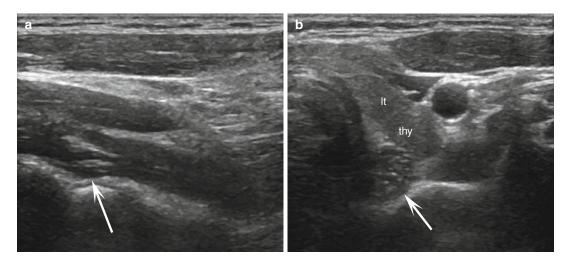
(a, b) Ultrasound of the cervical esophagus. (a) Longitudinal and (b) transverse views of the cervical esophagus (*arrow*) obtained using the left thyroid lobe (lt thy) as an acoustic window
